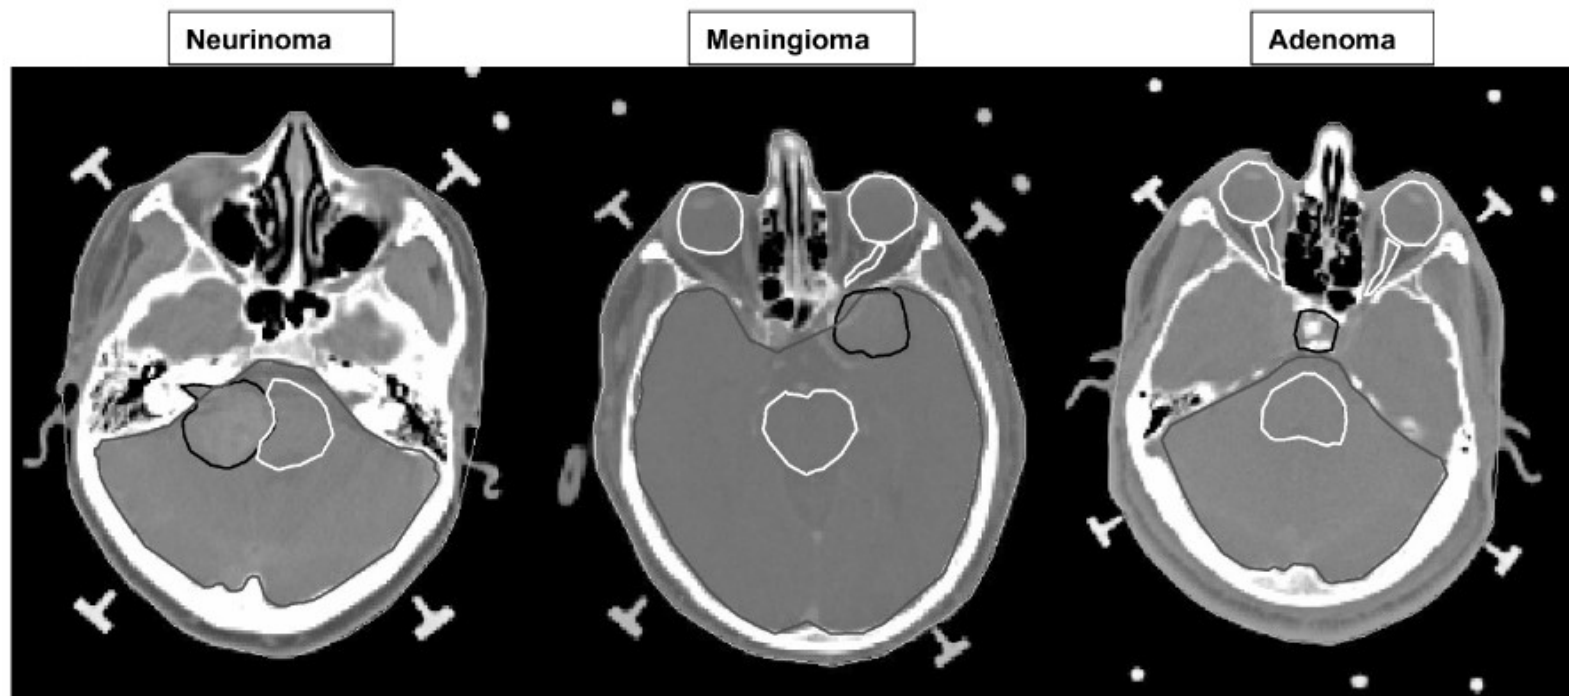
Shape and relative position of volumes of interest (target and OARs) for three cases included in the study. Data are shown on a CT slice corresponding to roughly the centre of the target.
